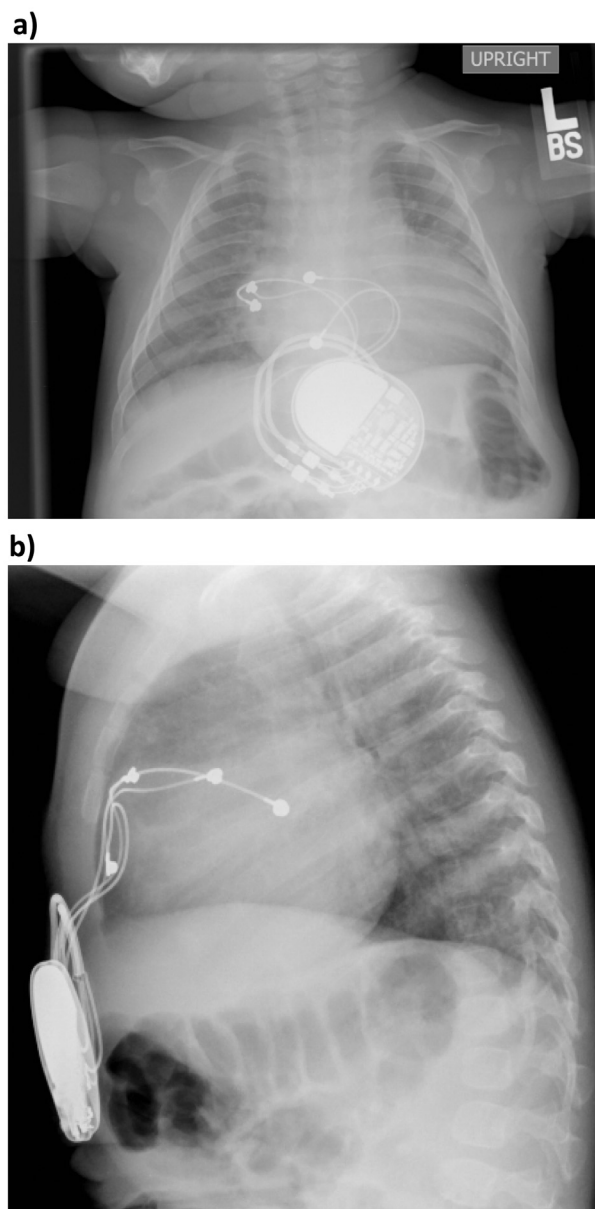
X-rays show typical lead placement in the antero-posterior (a) and lateral view (b) on the anterior aspect of the right atrium (RA) and RV in an infant with DDD pacemaker.
